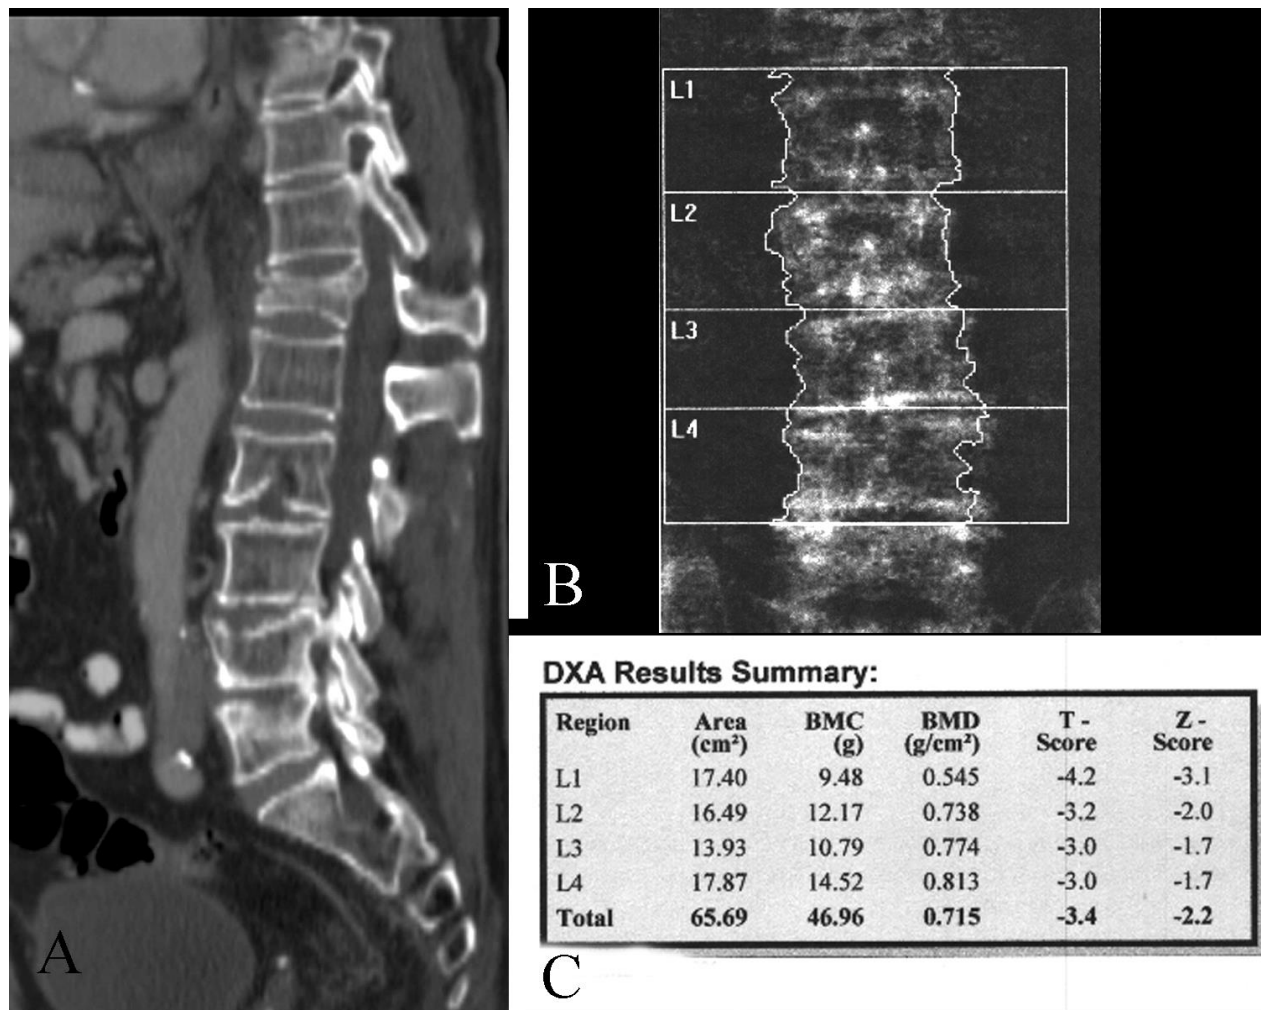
Incidentally discovered lumbar spine fragility fracture in an 81 year old man undergoing CT for abdominal pain. A. Sagittal reformatted CT examination shows T12, L2, L4, and L5 fractures. B. AP view of the patient's spine from his DXA study. C. Results summary from the DXA study showing osteoporosis.
